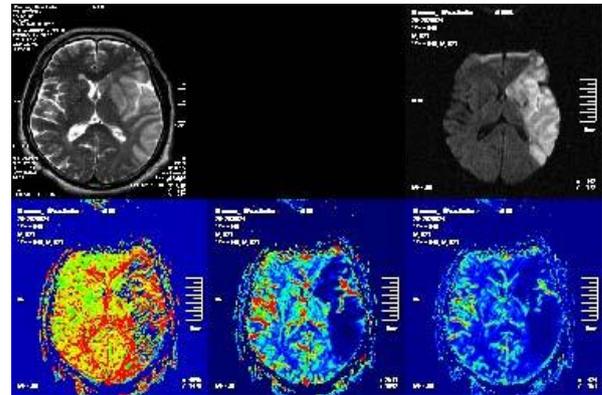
The deficit areas rCBV ↓, rCBF ↓, rTTP ↑ in the DSK perfusion examination in the patient with a right ASM infarction on T2A and DWI.
